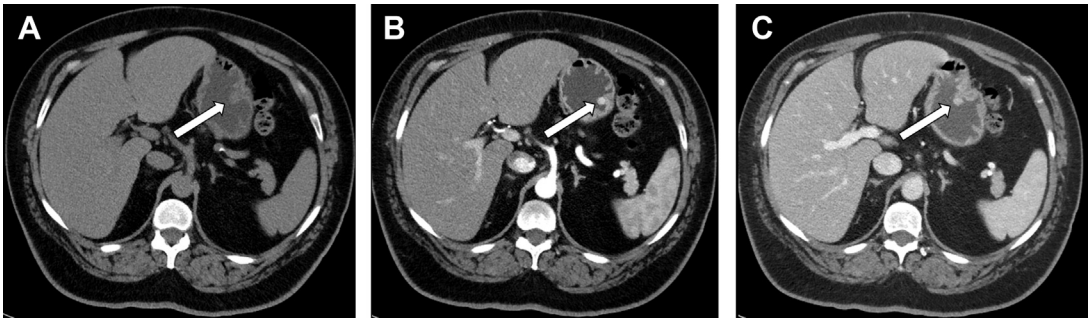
CT images in noncontrast (A), arterial (B), and portal venous (C) phases demonstrate a small enhancing polyp in the stomach (arrow), subsequently biopsied and found to represent gastric NET.
